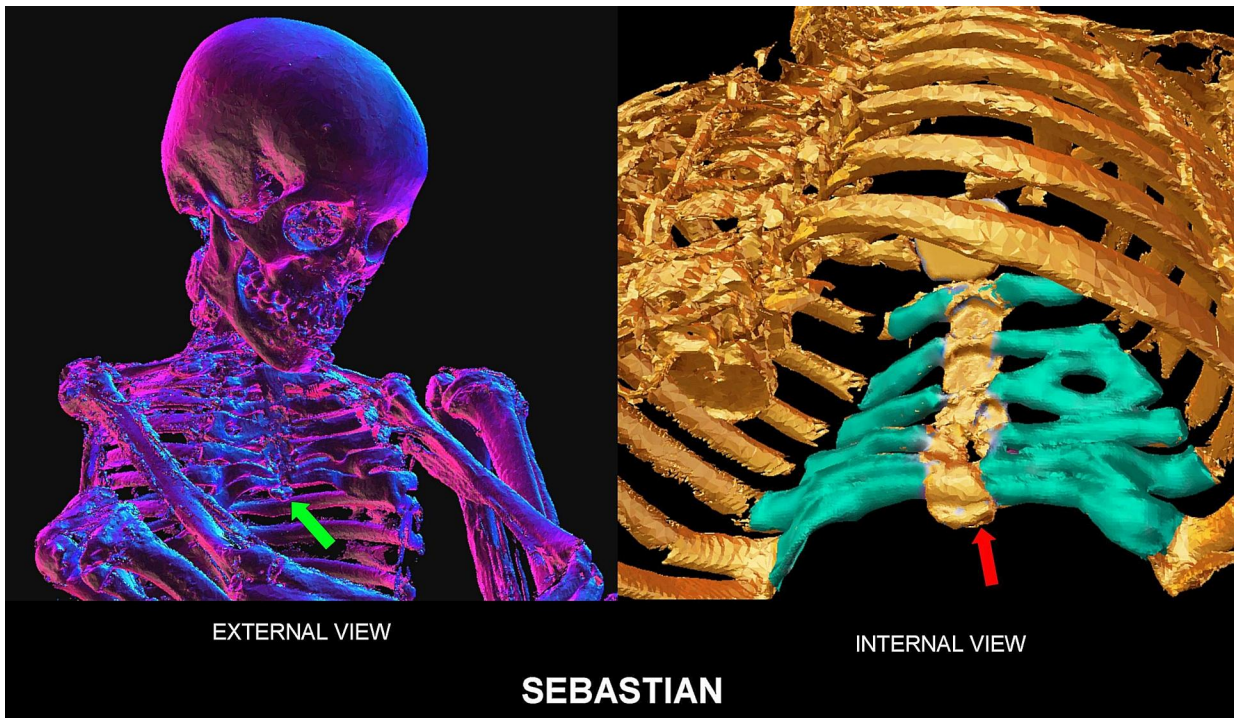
3D CT of thoracic cage highlighting deformed, horizontally orientated robust costal cartilages with U-shaped deformity causing pectus excavatum. *Arrows* point to xiphisternum.
